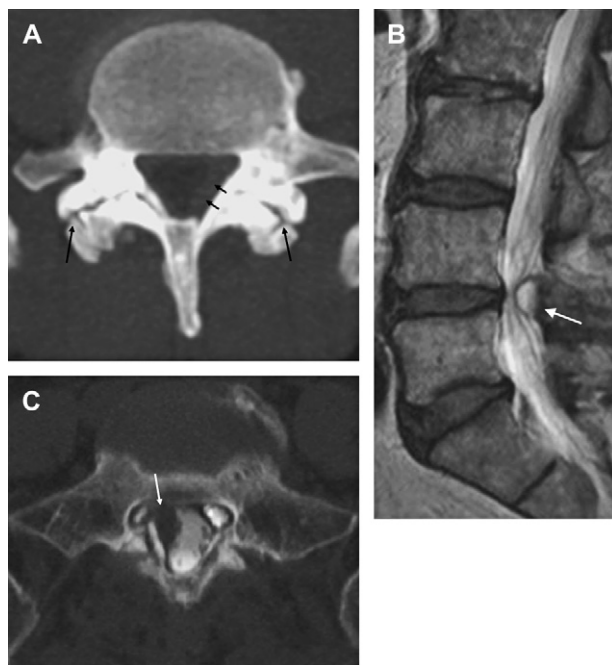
Facet joints. (A) Facet arthropathy. Axial CT. Bilateral hypertrophic facet joint changes (*long arrows*) in an asymptomatic patient. Note faintly visualized ligamentum flavum thickening (*small arrows*). (B, C) Synovial cyst. Sagittal T2 (B)—a rounded cystic lesion (*arrow*), which on axial CT myelogram (C) shows right-side posterior epidural impression on thecal sac, abutting the facet joint (*arrow*).
